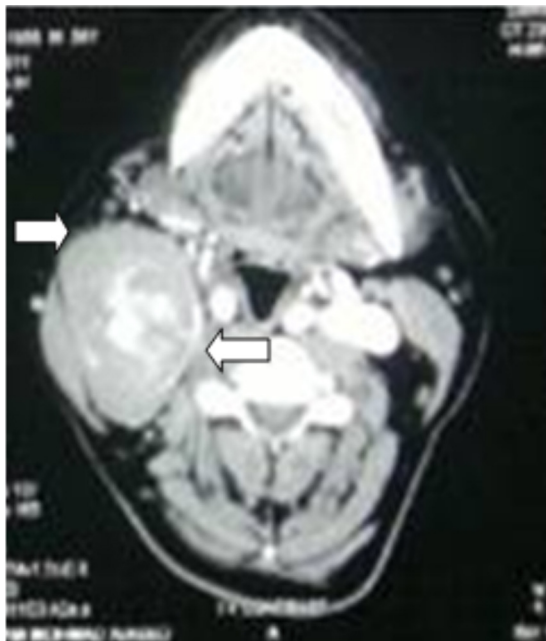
Axial CT imaging demonstrating large well defined mildly enhancing soft tissue mass.
